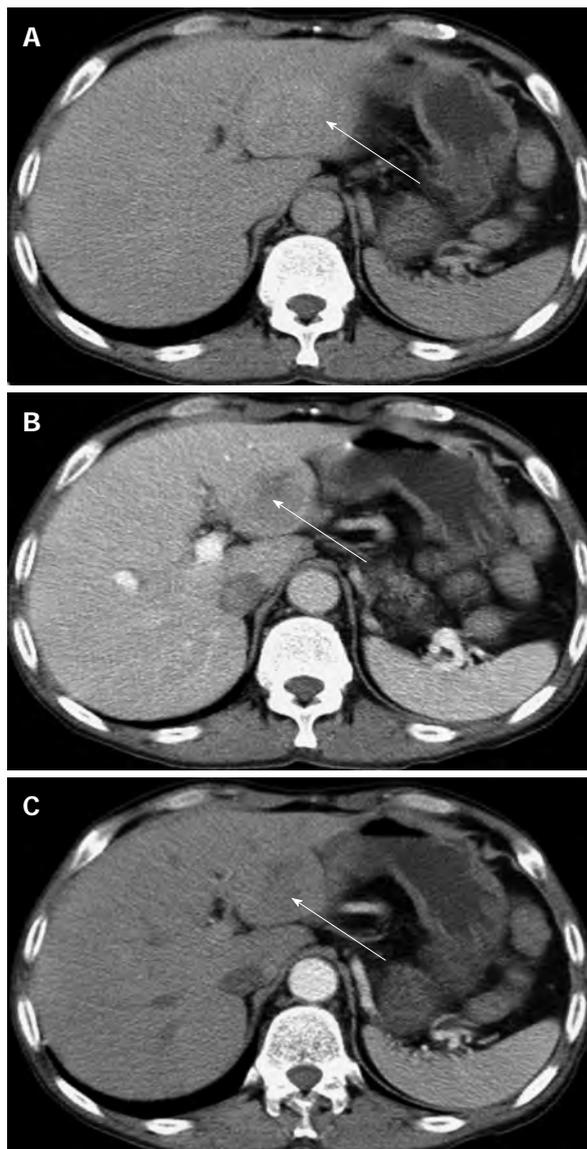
Abdominal computed tomography scan shows a mass in segment III of the liver. A: Hepatic equilibrium phase; B: Portal venous phase; C: Hepatic arterial phase. The arrows indicate the tumor in the liver.
